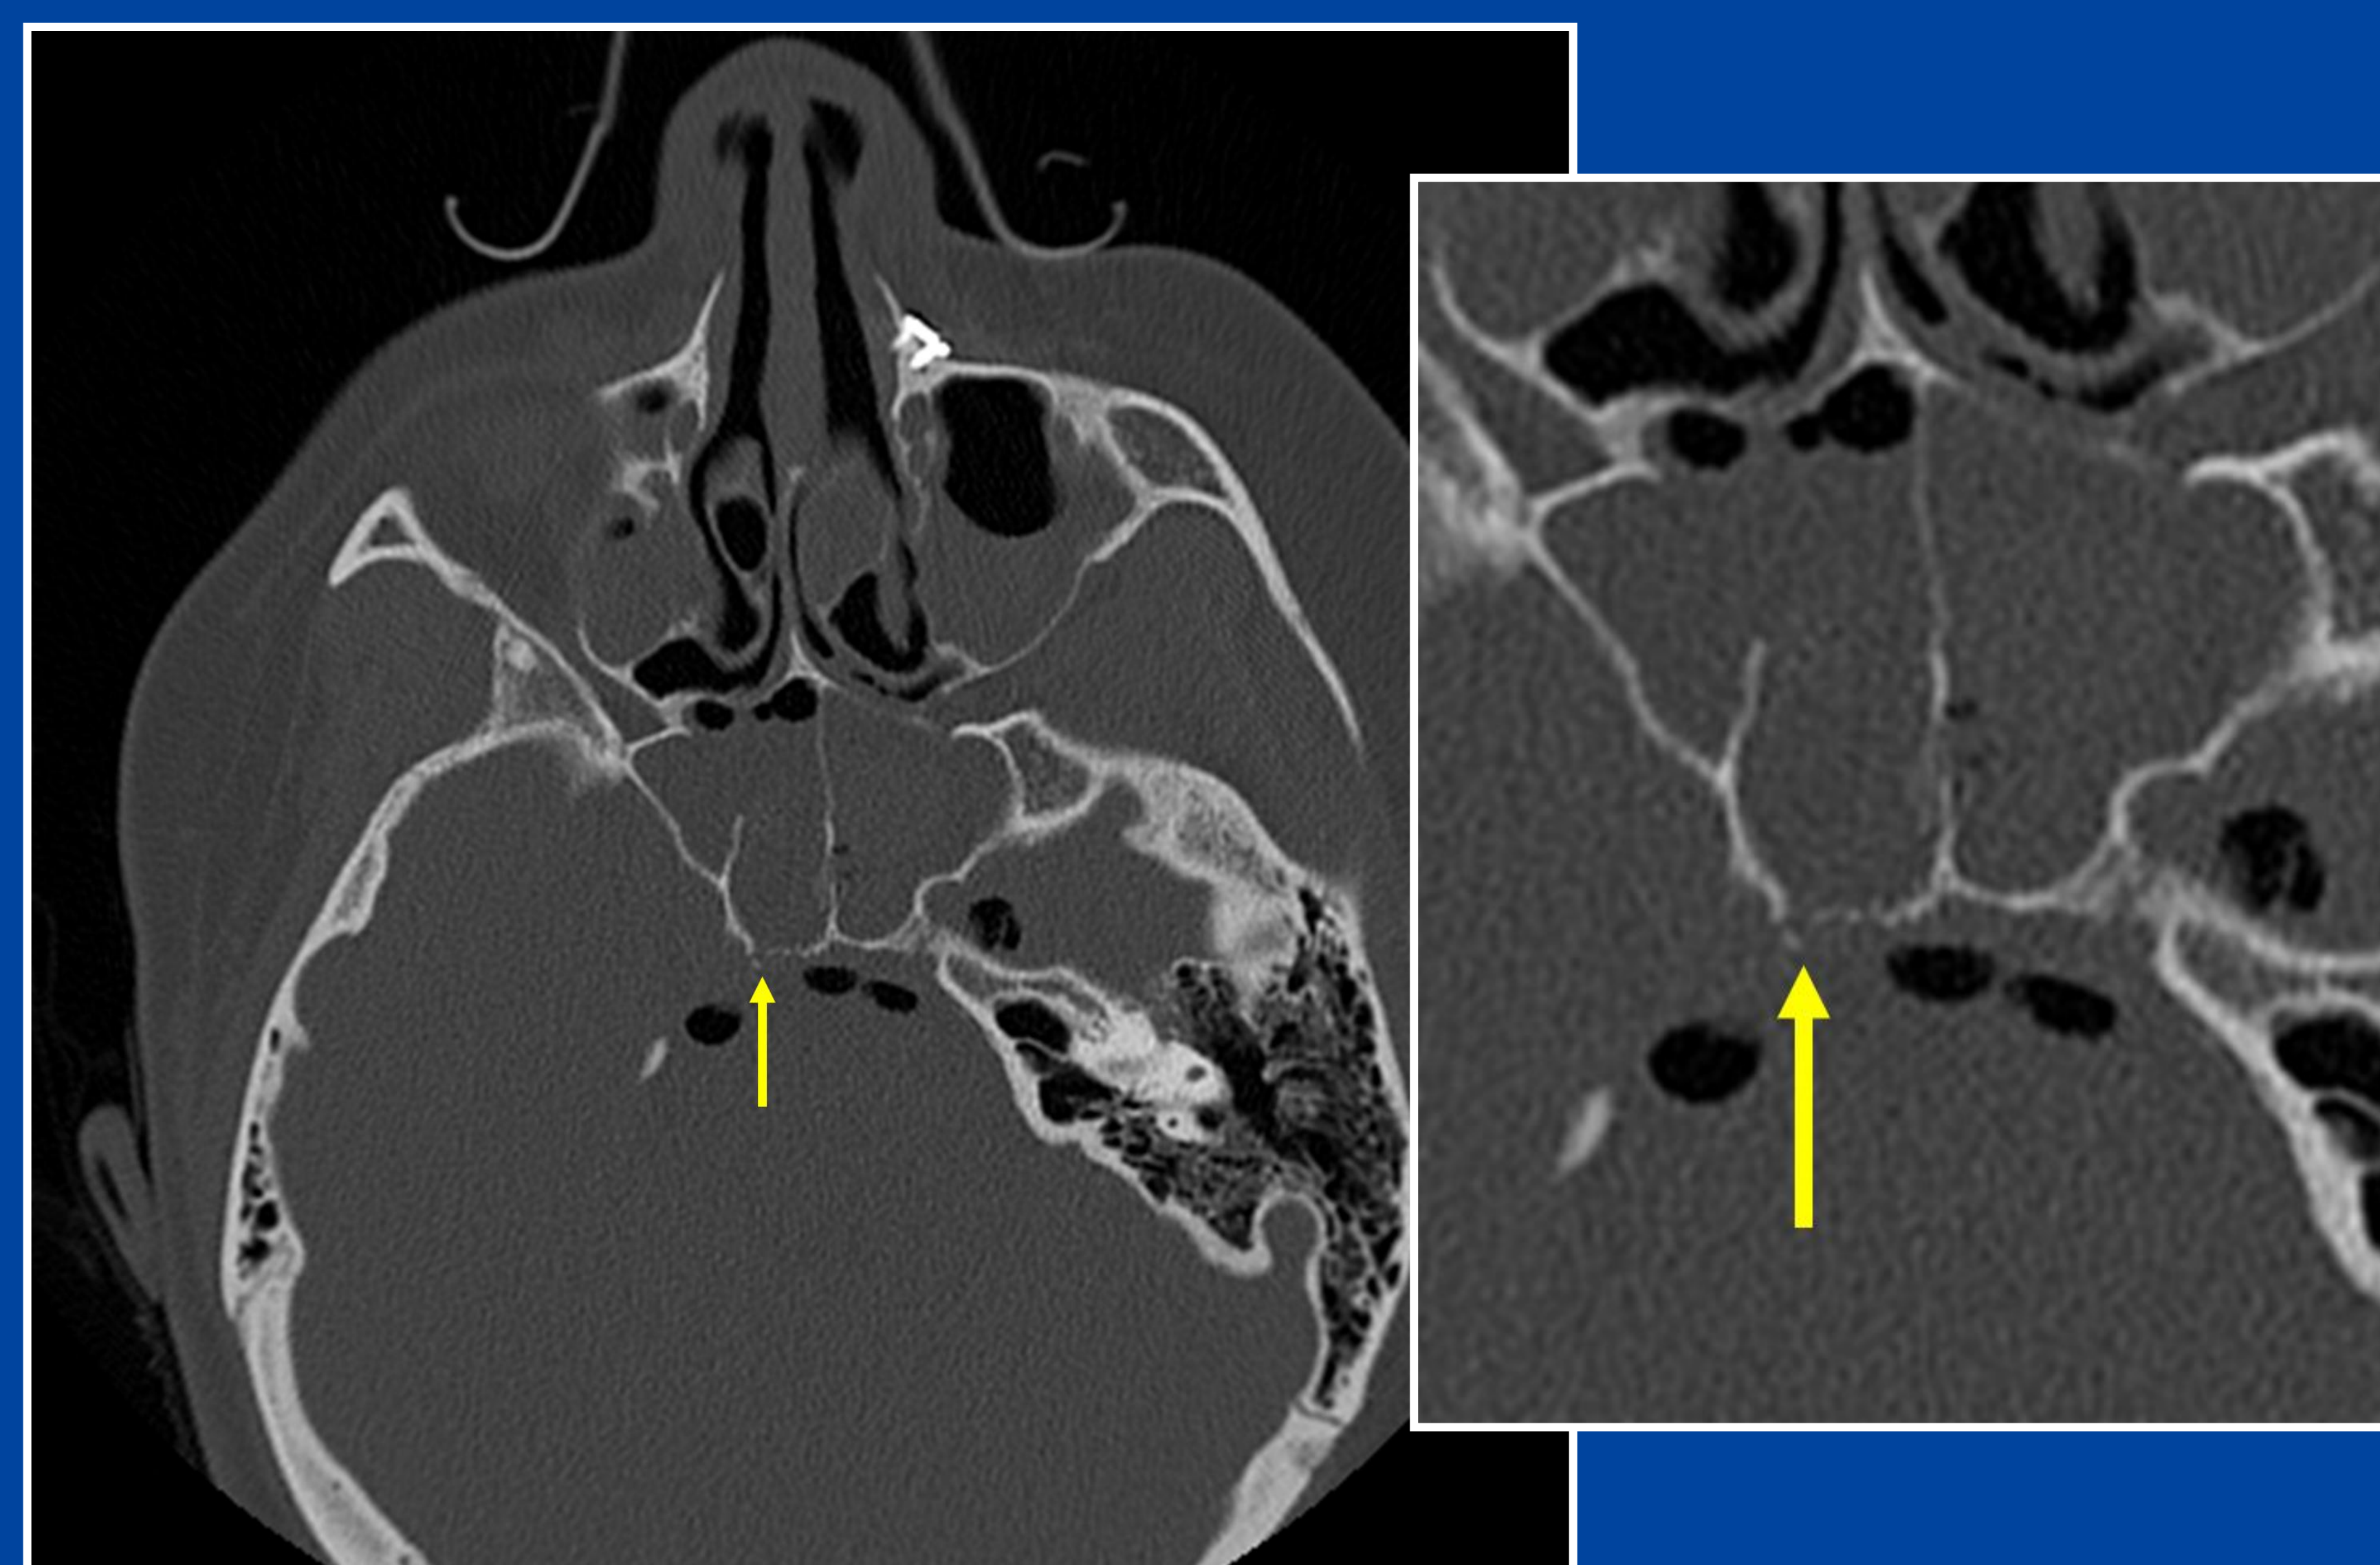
Fine-cut axial CT image demonstrating disruption of the posterior-lateral aspect of the right sphenoid lamina. Note the presence of pneumocephalus adjacent to the defect.
